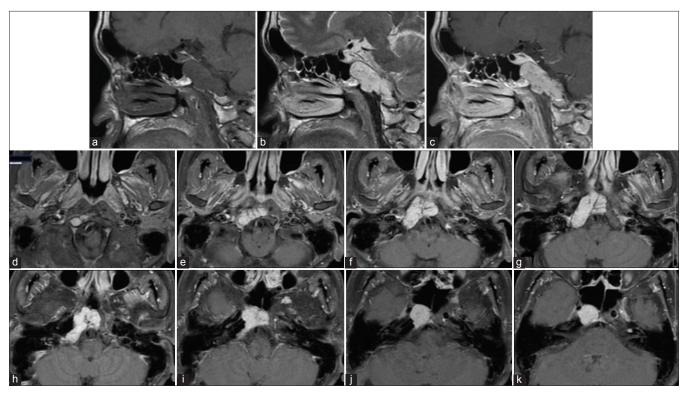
(a) Magnetic resonance imaging showing hypointensity on T1-weighted imaging and (b) hyperintense components on T2-weighted imaging in the lesion. (c) After gadolinium administration, the tumor is markedly enhanced in a homogenous fashion. (d-k) The axial images show the tumor area. On the upper side, the tumor became markedly enhanced in a homogenous fashion. On the upper side, the tumor protrudes in the sphenoidal sinus.
